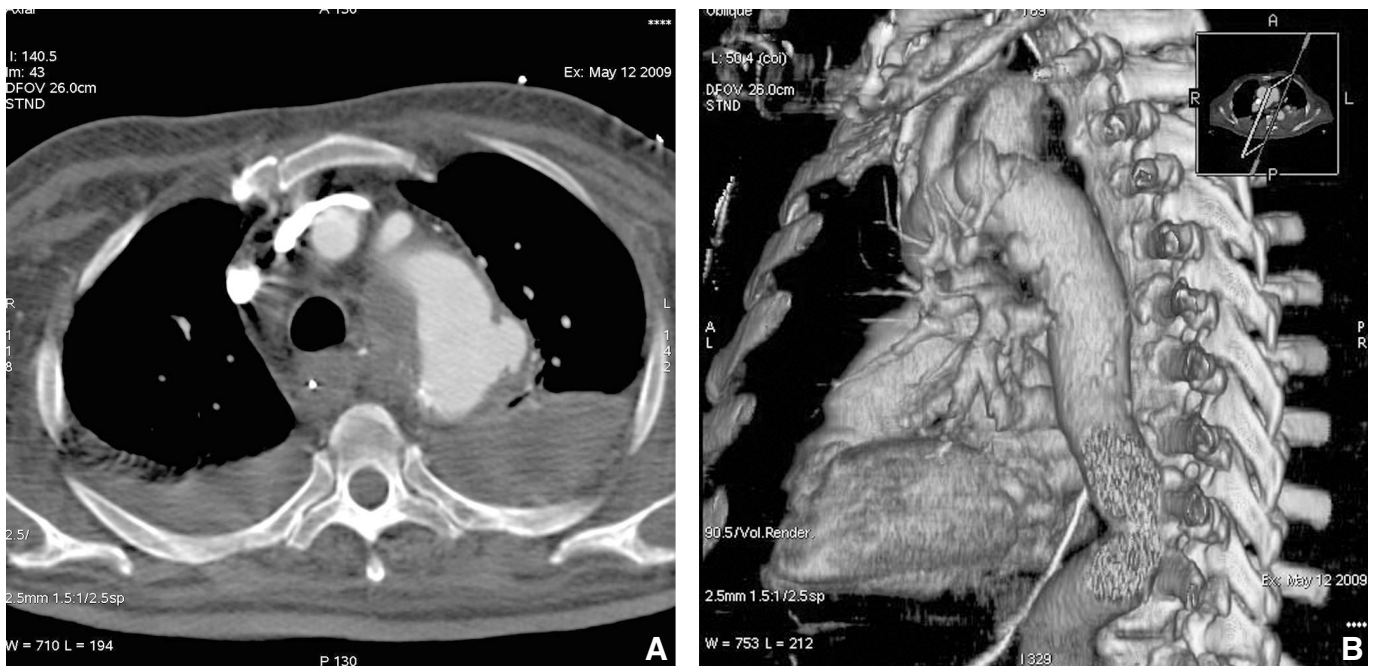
3D Volume Rendering oblique sagittal reconstruction (A) in a 81-years old man with infective aneurysms of descending aorta (arrows). The corresponding axial scan (B) shows a saccular focal dilatation of isthmus of aorta. Mediastinal and bilateral pleural effusions are also evident. CT findings were consistent with acute contained rupture of infective aneurysm.
